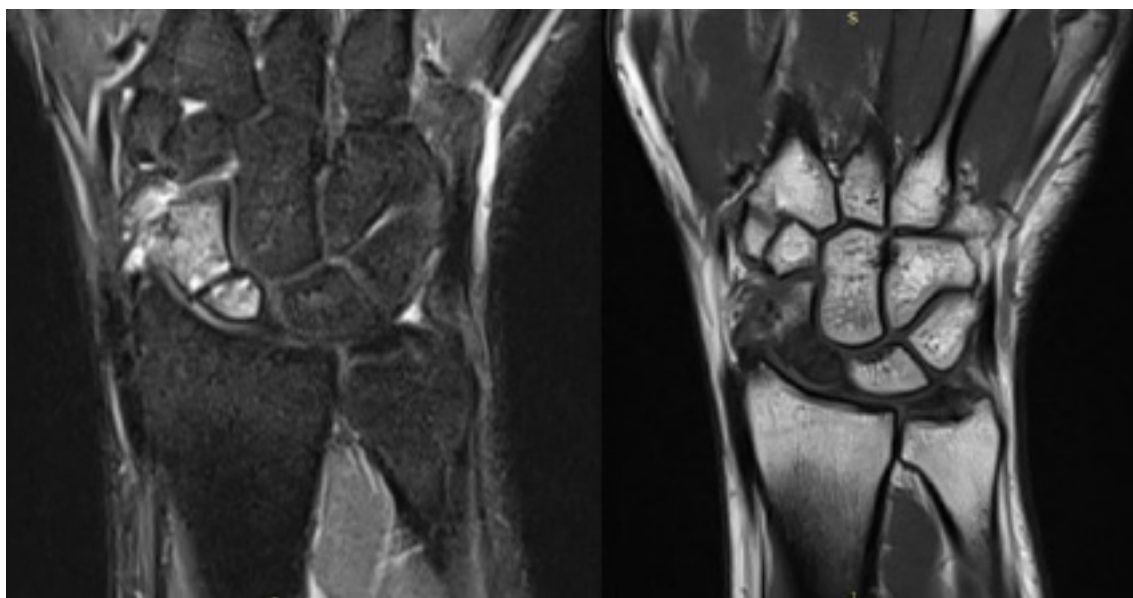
The magnetic resonance images showed the avascular necrosis of the scaphoid non-union.
